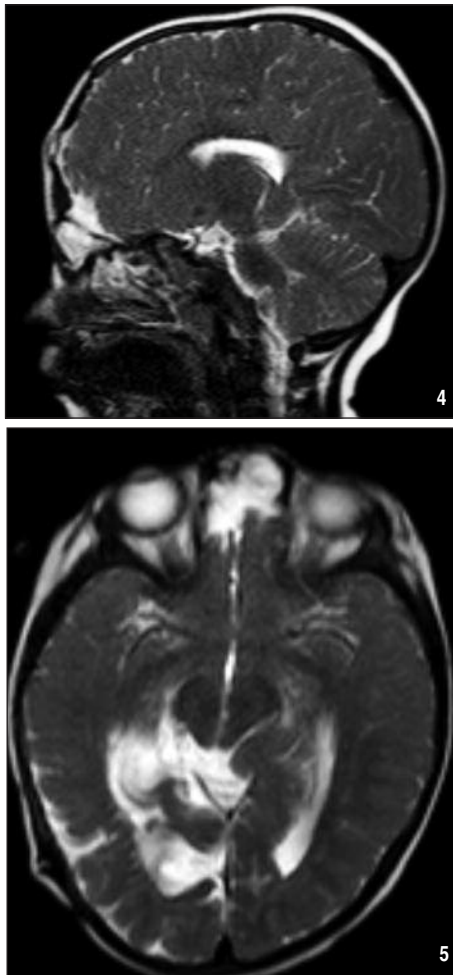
Postoperative MRI showed reconstruction of the crania and dura.
